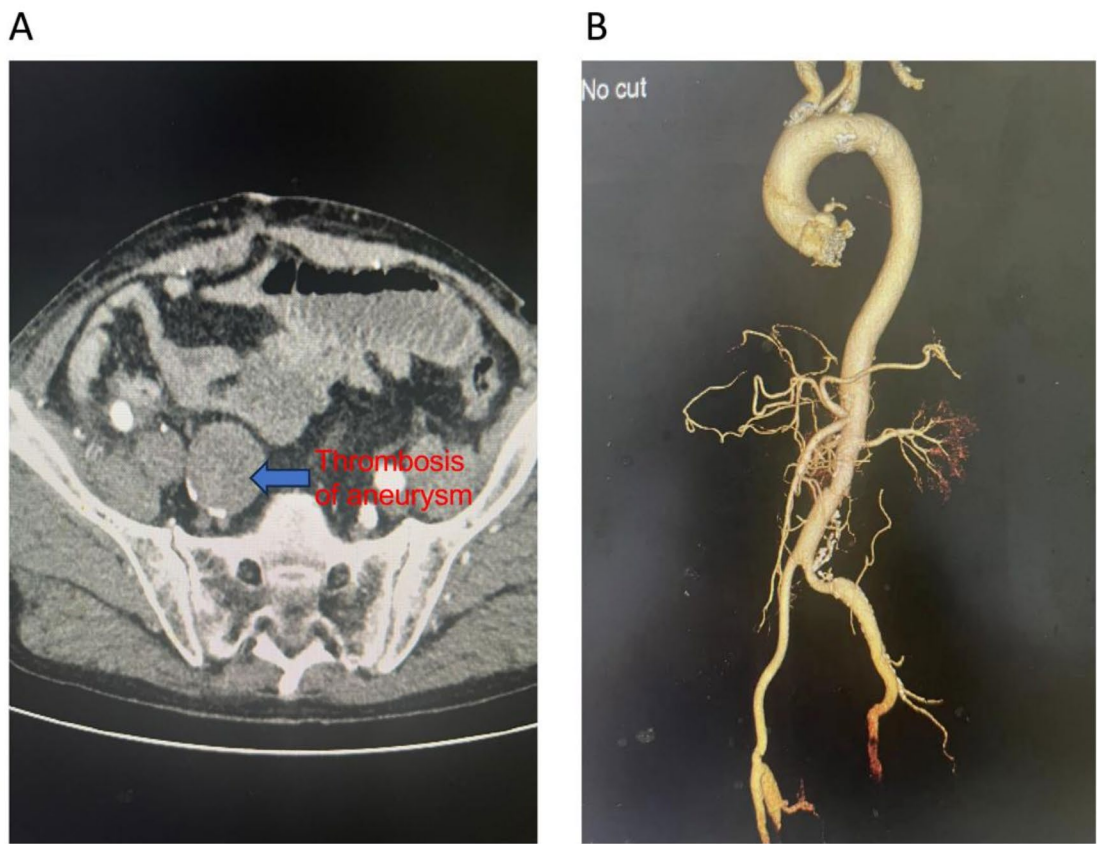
A. Three-dimensional reconstruction of CTA after operation indicates thrombosis of right internal iliac aneurysm. B. CTA three-dimensional reconstruction of blood vessels after operation
